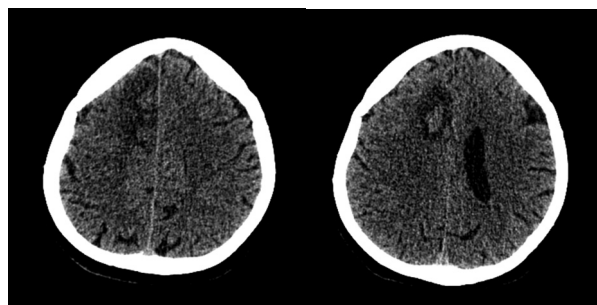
Control CT of the brain performed on the fifth day, cortico-subcortical infarction in the basin of the right anterior cerebral artery with signs of hemorrhagic transformation
